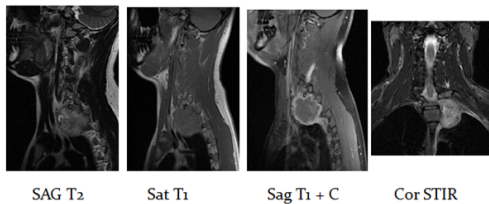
21 year old male patient presented with the history of left upper limb pain and abnormal sensation since 2 months, MRI of cervical spine reveals, well defined rounded left paraspinal mass lesion with peripheral enhancement on post contrast study with bony destruction involving transverse process of D2 vertebrae - Imaging features are indicative of Malignant peripheral nerve sheath tumour.
